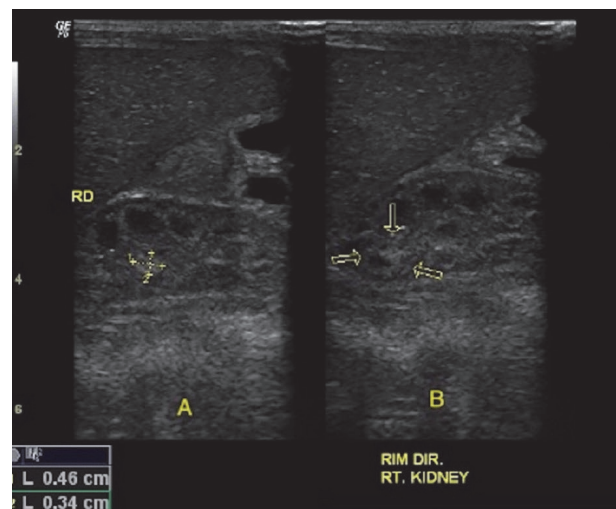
Ultrasonographic assessment of the first patient performed at 26 days of life demonstrating a hyperechogenic oval image suggestive of a fungal ball in the upper calyx group of the right kidney (delimited by the yellow arrows in B and being measured by the calipers in A).
